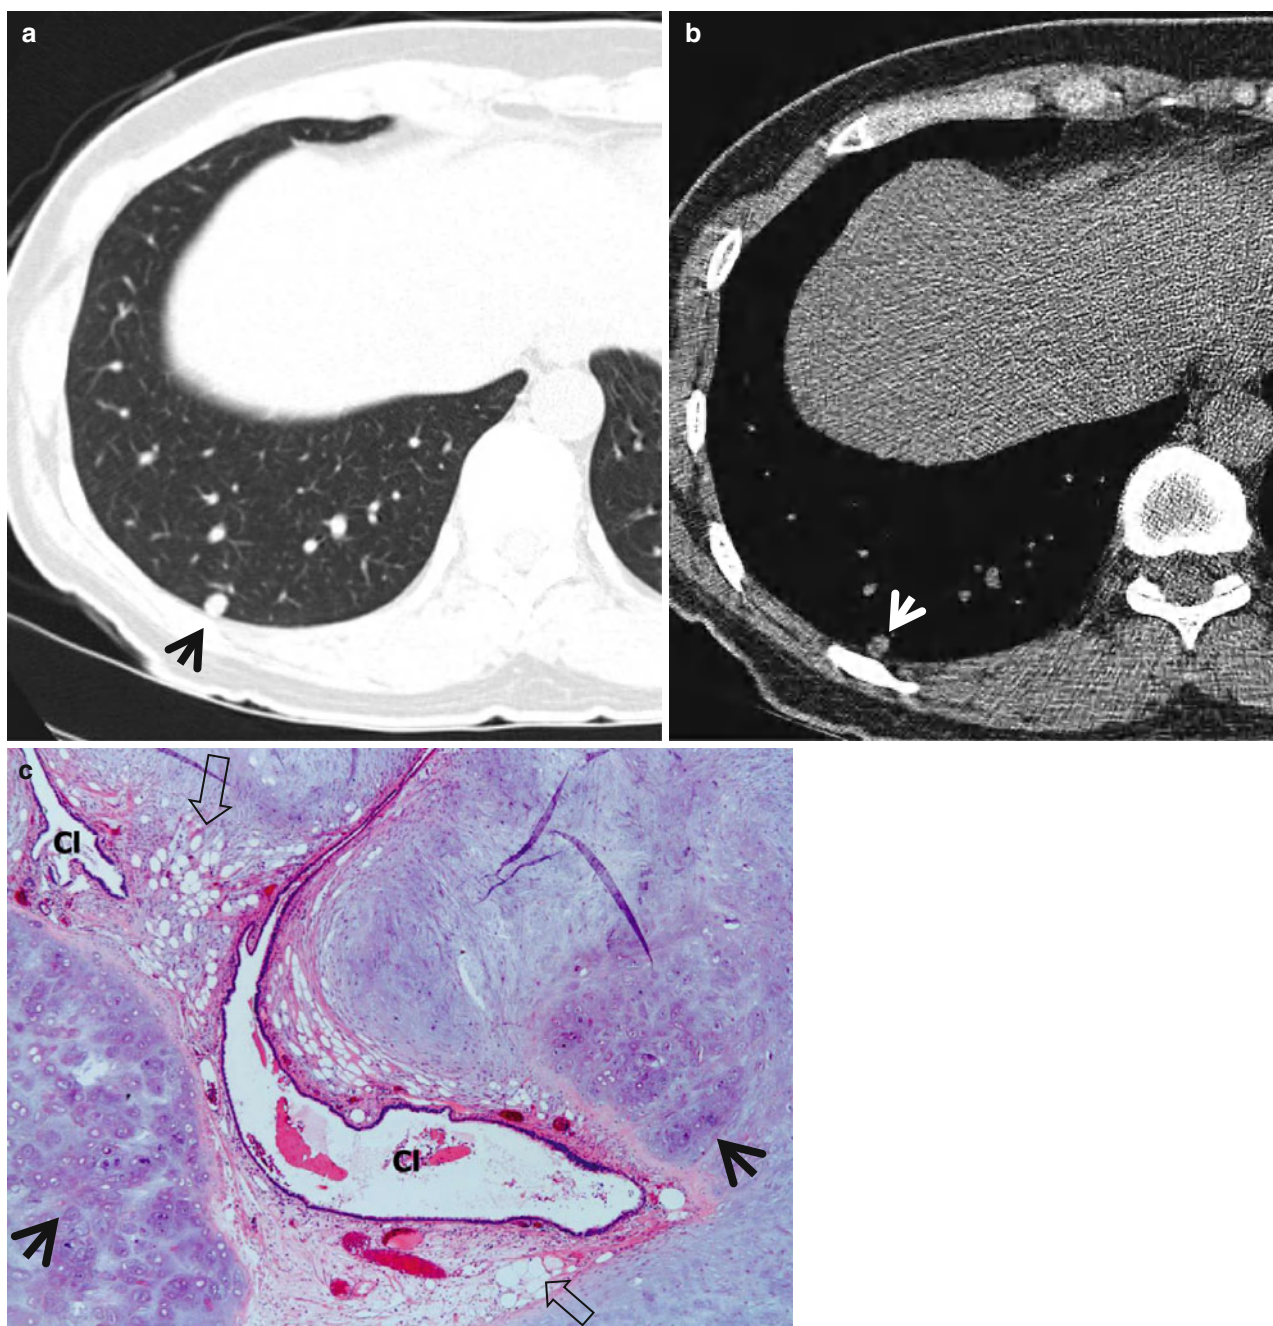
Chondroid hamartoma in a 40-year-old woman. (a, b) Lung (a) and mediastinal (b) window images of CT scan (5.0-mm section thickness) obtained at level of lower dome show an 8-mm-sized well-defined nodule (*arrows*) in posterior basal segment of the right lower lobe. Please note fat and calcification attenuation areas within nodule.
